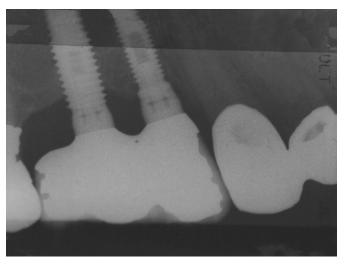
Pre-operative radiograph that demonstrated approximately 1–2 mm of bone loss around the osseointegrated implants in the right posterior maxilla.
